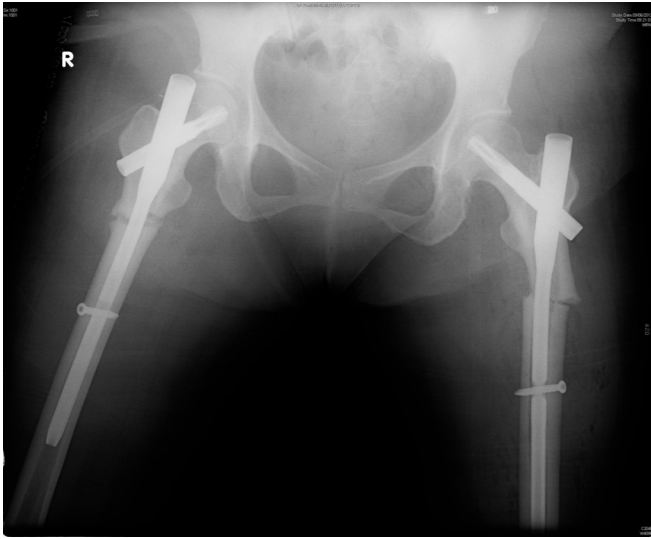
Anteroposterior X-ray showing fixation of atypical fractures using standard nails.
